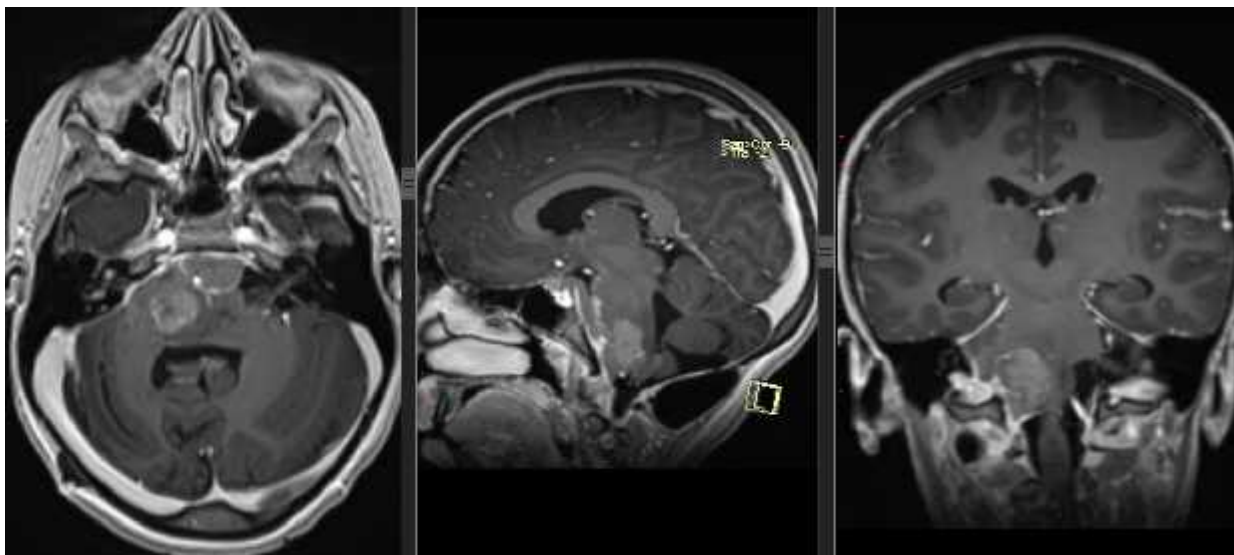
Pacient L., 9 years. Postoperative MRI scan. Explication in text
